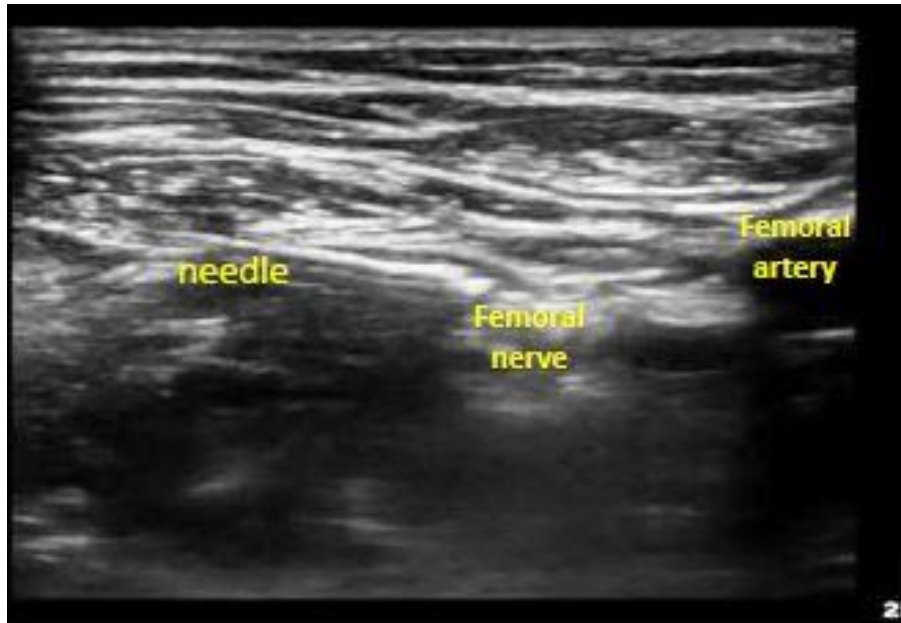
Ultrasound view of needle advancement towards the fascia iliaca
